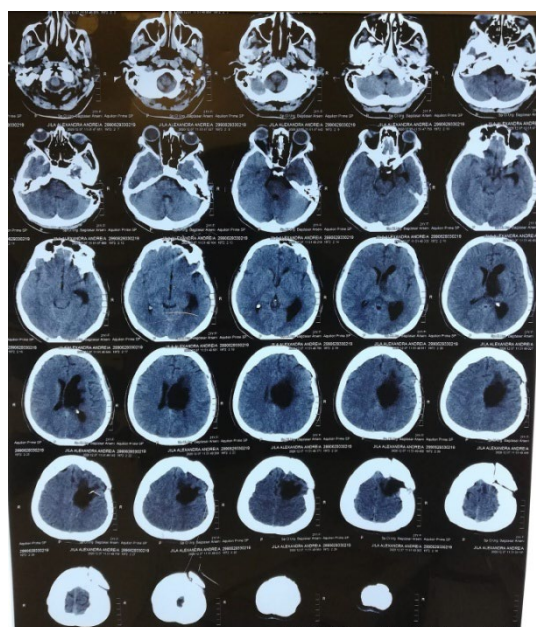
Control CT examination on 07.12.2020 (from THEBA Neuro -Rehabilitation Clinic Division)
